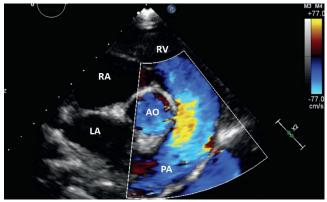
(*Continued*) (d) Moving the baseline up to maximize velocity in the downward direction to over 200 cm/s does not resolve the problem. This is aliased flow, exceeding the Nyquist limit with no discernable direction of flow or peak velocity. (e) Moving the baseline down does not remedy the situation. There is still no discernable direction or peak velocity. (f) Changing to CW Doppler allows higher velocity to be recorded. Peak velocity in a downward direction can now be determined.
